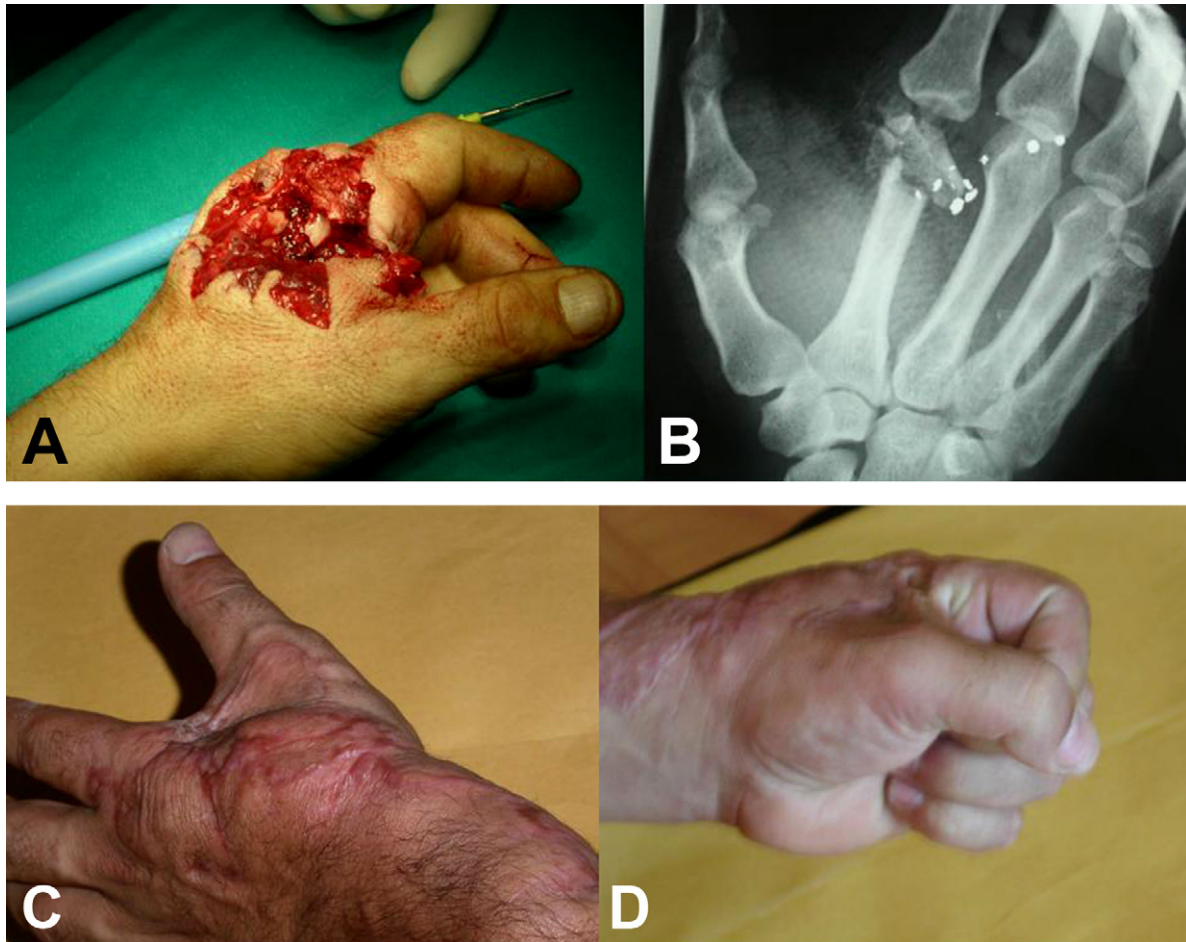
(A) A 24-year-old man with a gunshot injury of the left hand (patient 15). (B) Preoperative radiograph show a comminuted fracture of the second metacarpal head. One stage immediate reconstruction was done using mini external fixation of the fracture and the distal radial artery fasciocutaneous perforator-based flap. (C and D) Very good postoperative result.
